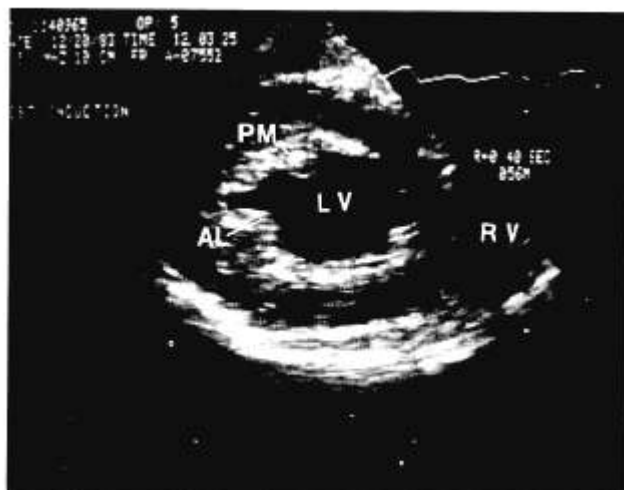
A stop-action, short-axis echocardiogram of the left ventricle at the level of the papillary muscles. This image was produced with a transesophageal transducer inserted 35–40 cm from the incisors. LV = left ventricle; RV = right ventricle; AL = anterolateral papillary muscle; PM = posteromedial papillary muscle. The corresponding imaging plane in figure 3 is number 3.
